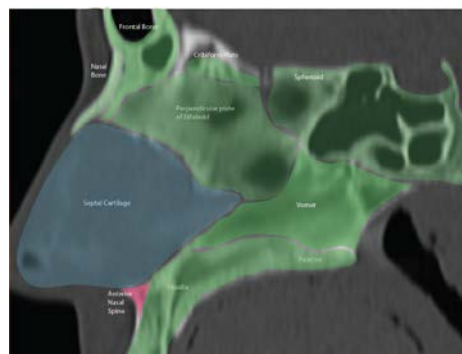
CT with anatomical units of the nasal septum
